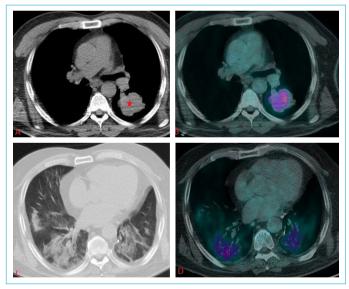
A 70-year-old male with lung cancer treated with surgery, chemotherapy and radiotherapy. PET CT was performed for the response of the disease to treatment and possible recurrence. (a) Non-contrast chest CT and (b) PET CT show a mass in the left lower lobe superior segment (star). (c) CT shows bilateral multifocal areas of patchy consolidation, predominantly peripheral and localized in lower lobes. (d) PET CT showed increased [18F]FDG uptake (SUV max 3.5).
